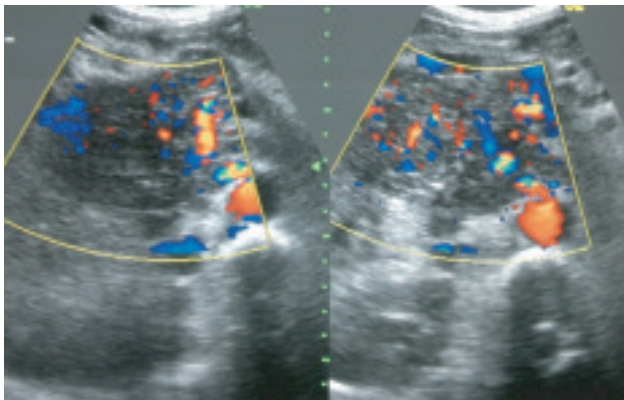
Increased vascularity on doppler
